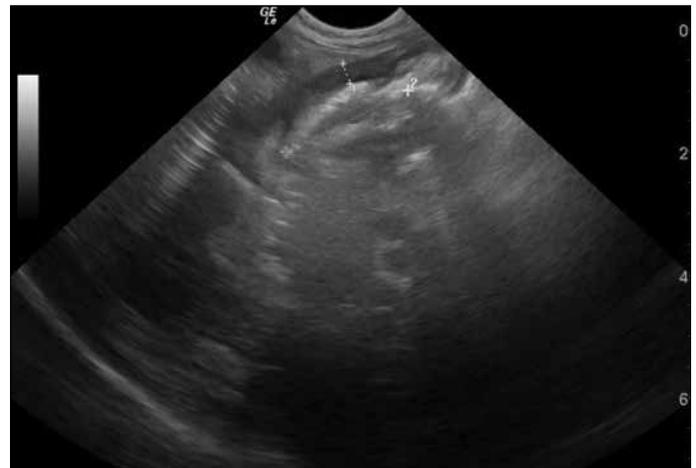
Abdominal ultrasonography of one of the patients showing elongation of the antropyloric channel with increase in wall thickening
